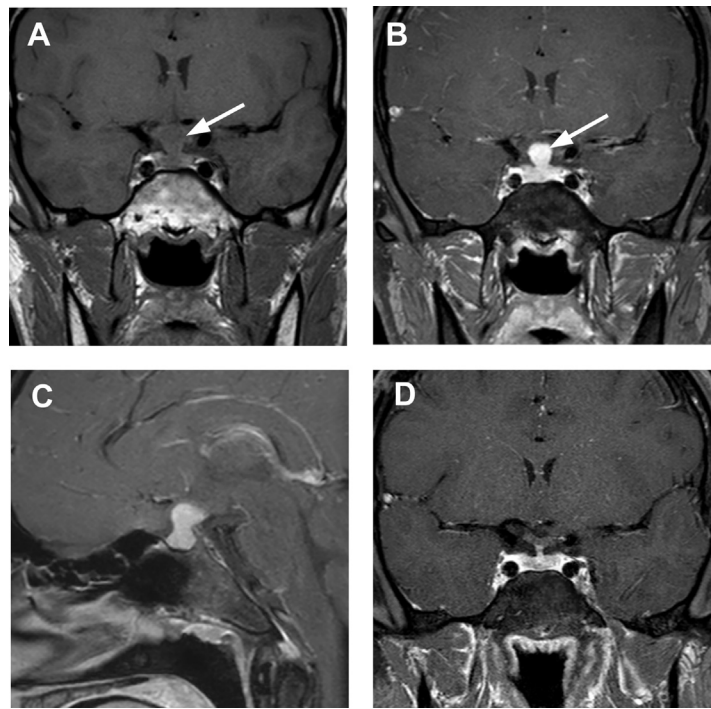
Pituicytoma. A 60-year-old man presented with trauma. CT showed an incidental sellar and suprasellar mass. (A) Sagittal MR imaging shows T1-isointense predominantly suprasellar mass (arrow) that displaces optic chiasm and compresses the anterior third ventricle. (B) Sagittal postcontrast T1-weighted image demonstrates homogeneous enhancement of the mass (arrow).
